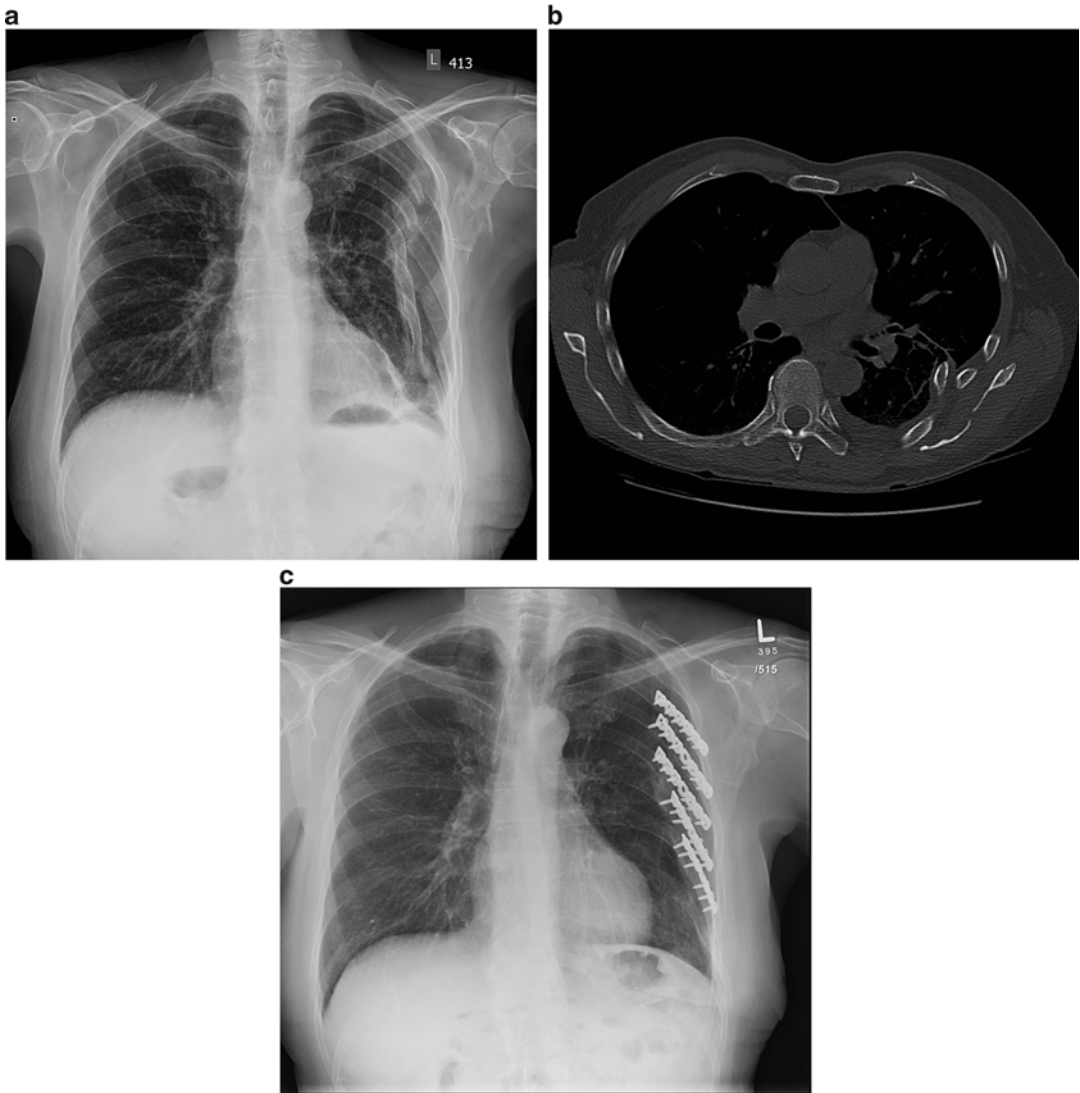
(a) A patient sustained multiple rib fractures with a flail segment and deformity. After nonoperative treatment, persistent pain, deformity, and instability resulted. Radiographs (a) and a CT scan (b) demonstrated
